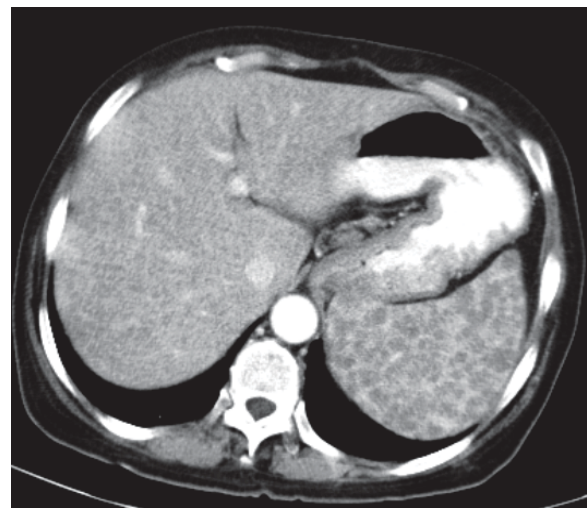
Abdomen computed tomography scan showed splenomegaly with multiple hypodense lesions and non-homogenous liver
